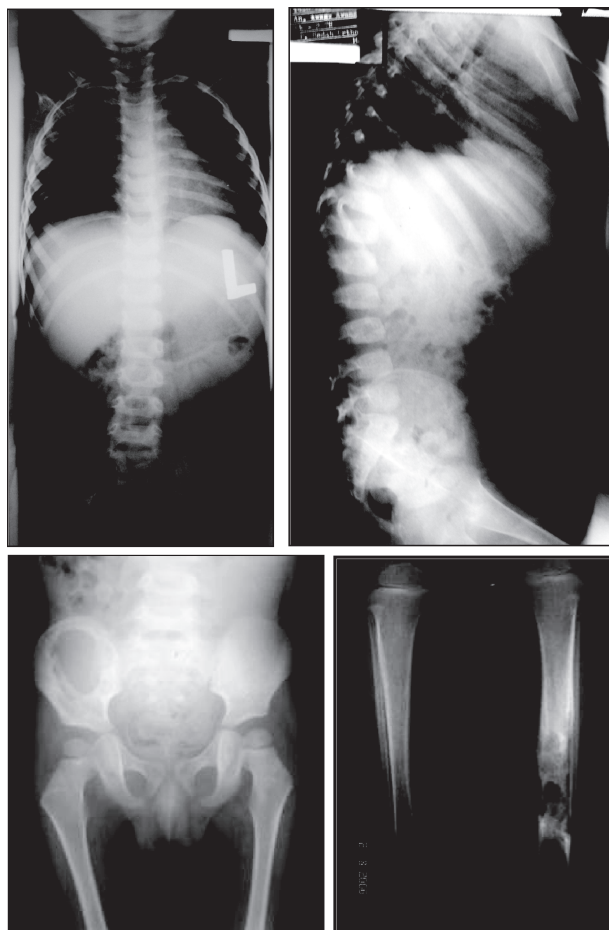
Radiographic examinations revealed infiltrate on the upper part of right hillus, lytic lesion in right iliac wing, destruction of the diaphyse and periosteal retraction of left tibia.
